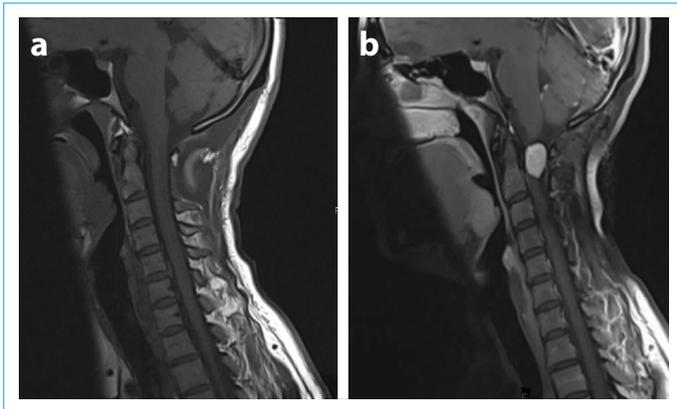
(a, b). Sagittal T1 (a) and contrast-enhanced T1 weighted, (b) magnetic resonance imaging showed an intradural extramedullary tumor at the craniovertebral junction.
